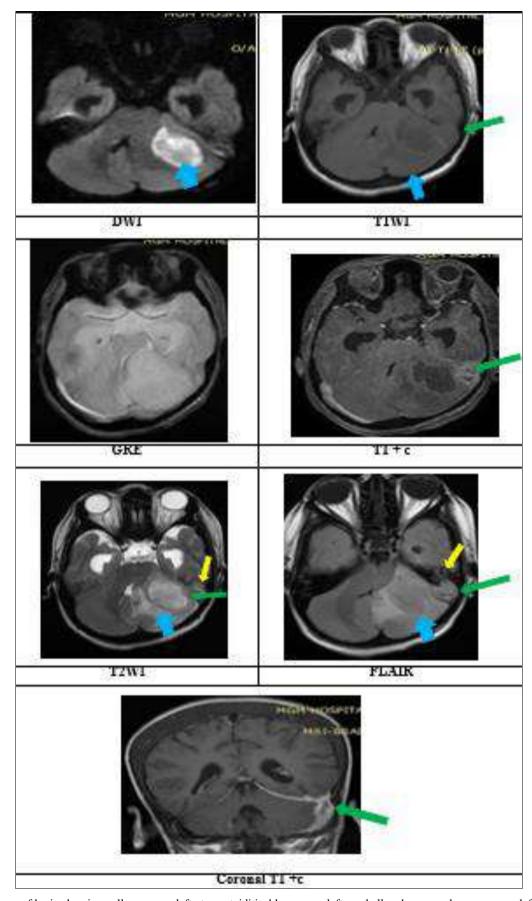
MR images of brain showing yellow arrow: left otomastoiditis, blue arrow: left cerebellar abscess and green arrow: left transverse and sigmoid sinus thrombosis along with tentorial and Dural enhancement
